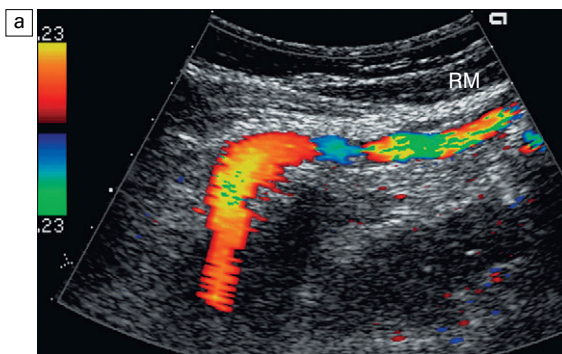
(a) Longitudinal colour Doppler image of a patient with portal hypertension. A large vein carries flow from the left portal vein towards the transducer. It courses along the falciform ligament and then turns caudad along the interior abdominal wall coursing towards the umbilicus, deep to the rectus muscles (RM). (b) Shaded surface display three-dimensional reformat of the upper abdominal solid organs and portal venous system. Flow in the main portal vein courses towards the liver but immediately channels into a large left portal vein (open arrow). Flow then continues anteriorly towards the anterior abdominal wall and down towards the umbilicus in a large recanalised paraumbilical vein (pink).
